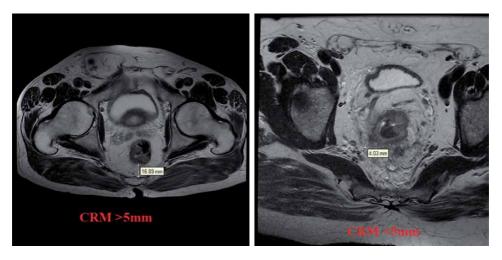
CRM- circumferential resection margin (axial T2 weighted MR images).
